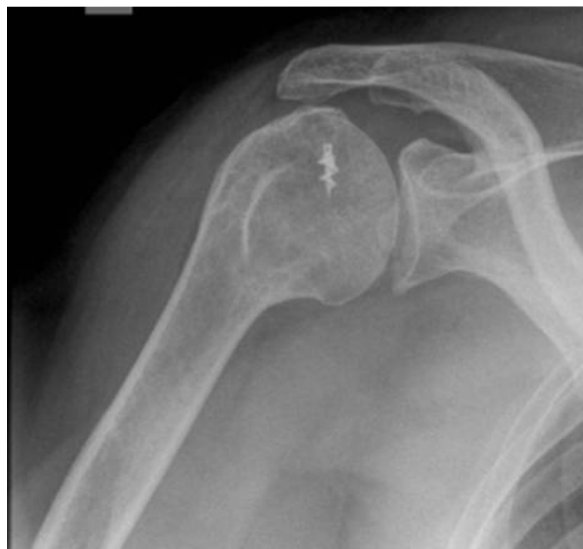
Post-operative radiograph showing improved joint contour following arthroscopic tuberoplasty
